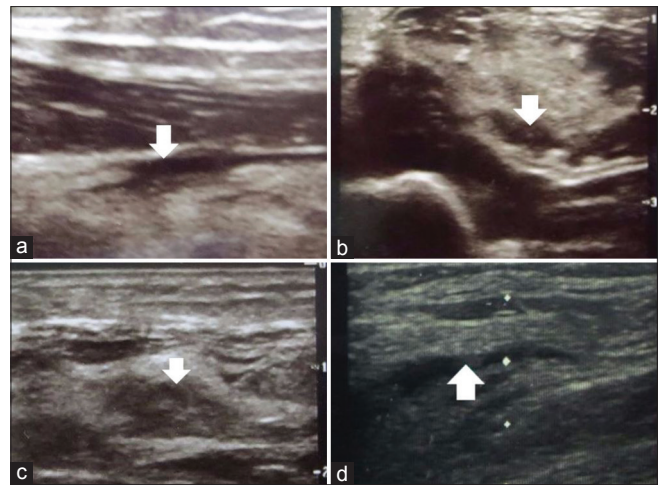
(a) Ultrasonography of thigh revealing a small pocket of hypo-echoic collection within the inter-fascial plane. (b and c) Ultrasonography of upper arm revealing bulky muscle which is heterogeneous in echotexture with loss of fibrillar pattern with few hypoechoic areas – collection pockets. (d) Ultrasonography of thigh done few days after intensive care unit admission suggestive of better delineation of muscle fibrillar pattern and relatively normal muscle bulk. Small pocket of collection is still there
